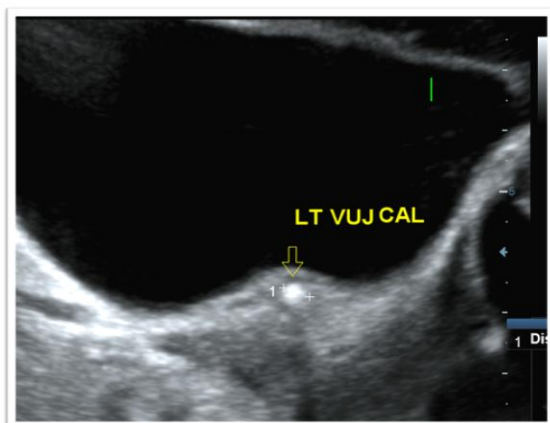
Grayscale ultrasound of the urinary bladder demonstrating a left vesicoureteric junction (VUJ) calculus with posterior acoustic shadowing.
